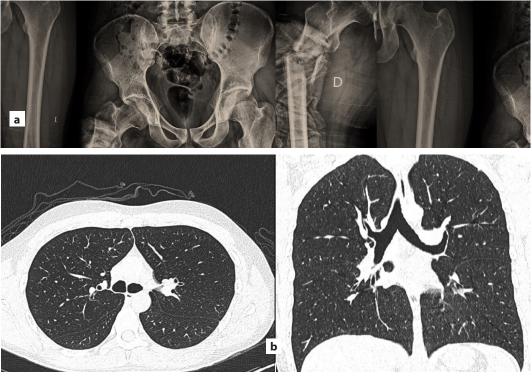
a. Pelvis and bilateral femur X-rays in anteroposterior projections that show the fracture of multiple fragments of the diaphysis in the proximal third of the right femur, displaced in varus, with thickening and periosteal reaction of the cortical in "Codman's triangle" with heterogeneous density and badly defined central radiolucent areas. b. Computed axial tomography of the chest.
